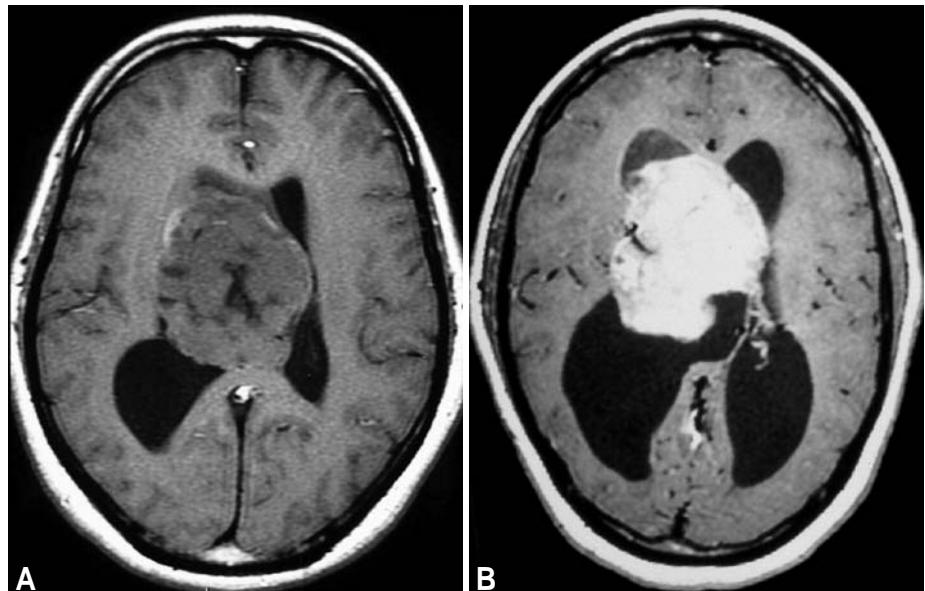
MRI of central neurocytoma. A A large tumour of the lateral ventricle with heterogeneous hypointensity on T1-MRI. B A large contrast-enhancing central neurocytoma in the region of the foramen of Monro (gadolinium injection).
